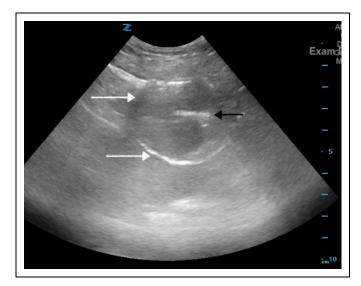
Ultrasound image demonstrates the OGT balloon (white arrows) with magnets (black arrow) in a patient with an abdominal wall to stomach depth of 2 cm.
